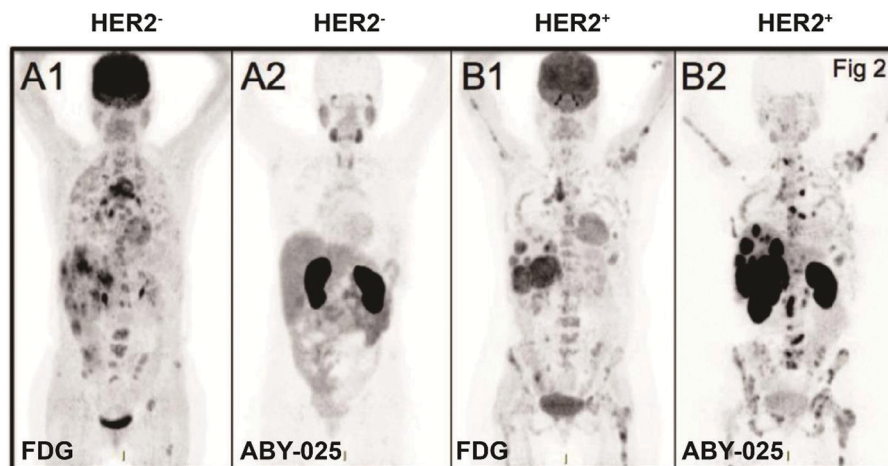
HER2-specific-affibody imaging in the clinical trial. Notes: PET imaging of HER2-negative patients (A) and HER2-positive patient (B) with  $^{18}\text{F}$ -FDG (A1, B1) and  $^{68}\text{Ga}$ -ABY-025 (A2, B2); standard uptake value (SUV) is normalized to 10 for all images; darker colors indicate higher uptake. Specific uptake and high contrast image is shown with  $^{68}\text{Ga}$ -ABY-025 compared to  $^{18}\text{F}$ -FDG-PET image. Adapted from ref. 35. Abbreviations: HER2, human epidermal growth factor receptor 2; ABY, affibody; SUV, standard uptake value; PET, positron emission tomography; and FDG, fluorodeoxyglucose.
